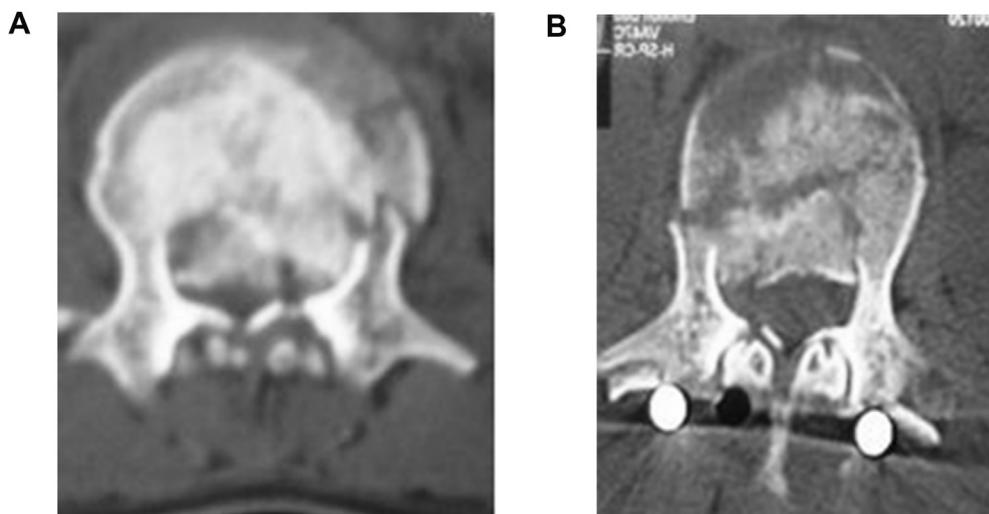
Canal clearance achieved by posterior short segment instrumentation and indirect reduction. 3a. Preoperative axial view. 3b. Immediate postoperative axial CT.
